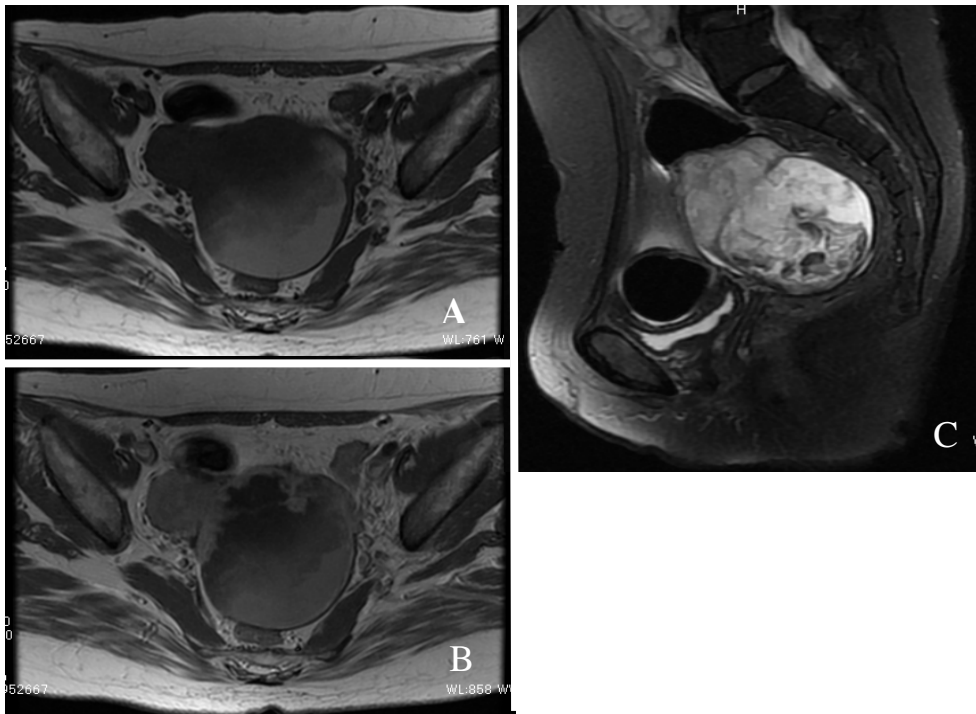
An axial MR image of the pelvis showing a left ovarian tumor in T1-weighted images (A) and in T2-weighted images (B), and the gadopentetate dimeglumine-enhanced T1-weighted images showing the enhancement of the intratumoral septa and solid components in ovarian tumor and pelvic lymph nodes (C).
